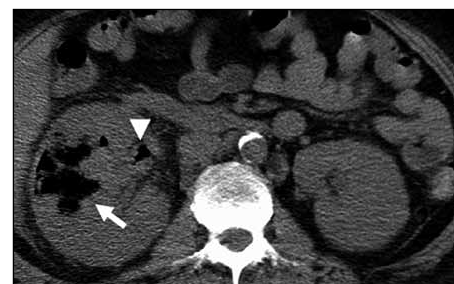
Axial non-enhanced computed tomographic scan of the kidneys showing right renal enlargement and presence of air in the renal parenchyma (arrow) and renal pelvis (arrowhead)
